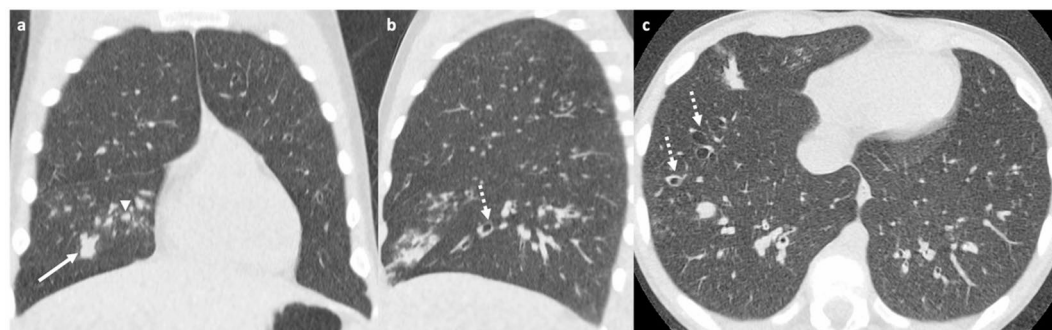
ULDCT chest assessment of structural lung pathology. Ultra-low dose CT chest images in lung windows with 2 mm reconstructed slices in a 12-year-old male with cystic fibrosis demonstrating structural lung changes assessed via Brody II scoring. Coronal inspiratory image (a) demonstrates mucus plugging (arrowhead) and dense parenchymal opacity (arrow) in the middle lobe. Sagittal inspiratory images (b) and axial inspiratory images (c) demonstrate cylindrical bronchiectasis (dashed arrow). Minimal breathing motion artefact is noted in the lung bases as these images were acquired without sedation or general anaesthesia and remain diagnostic for structural lung changes related to cystic fibrosis.
